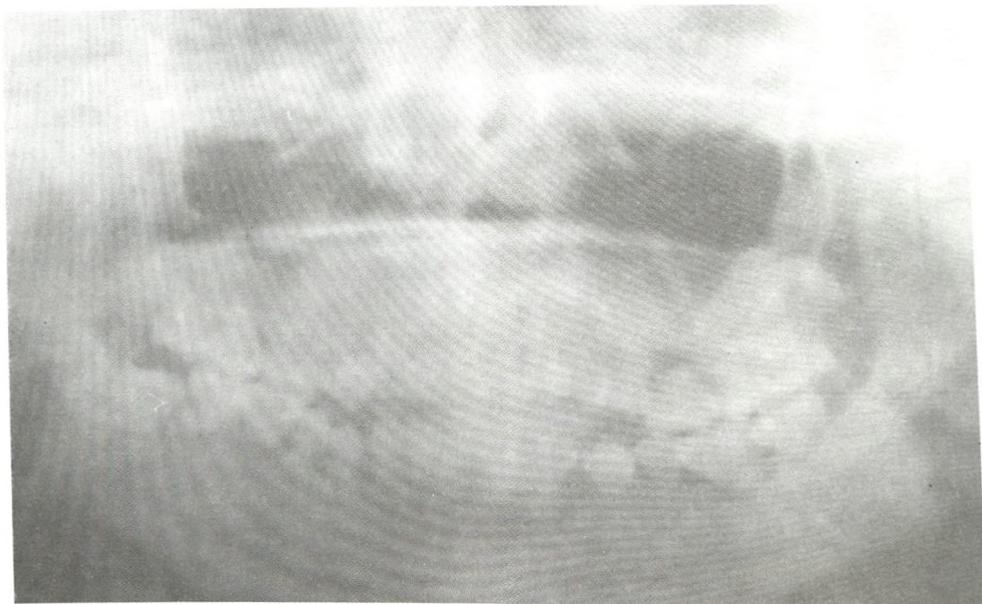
Dental orthopantomogram of case I shows rootless teeth with obliterated pulp chambers and multiple radiolucencies associated with root stubs. These features are characteristics of dentin dysplasia type I
